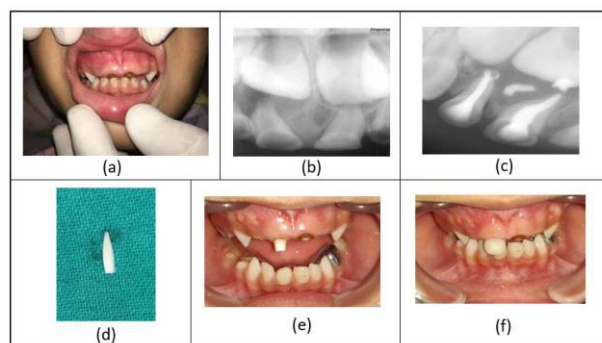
Biological restoration as a post and core: (a) preoperative picture; (b) preoperative radiograph; (c) pulpectomy performed w.r.t 51; (d) biological post preparation; (e) biological post cementation w.r.t 51; (f) post-operative strip crown restoration w.r.t 51.
